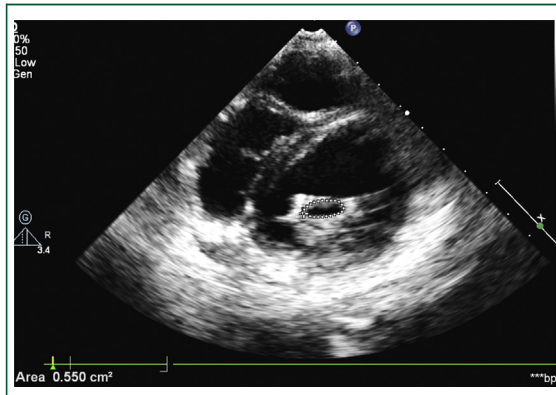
Planimetry for calculating mitral valve area in parasternal short-axis view in a case with severe mitral stenosis, area being 0.55 cm^2 .
